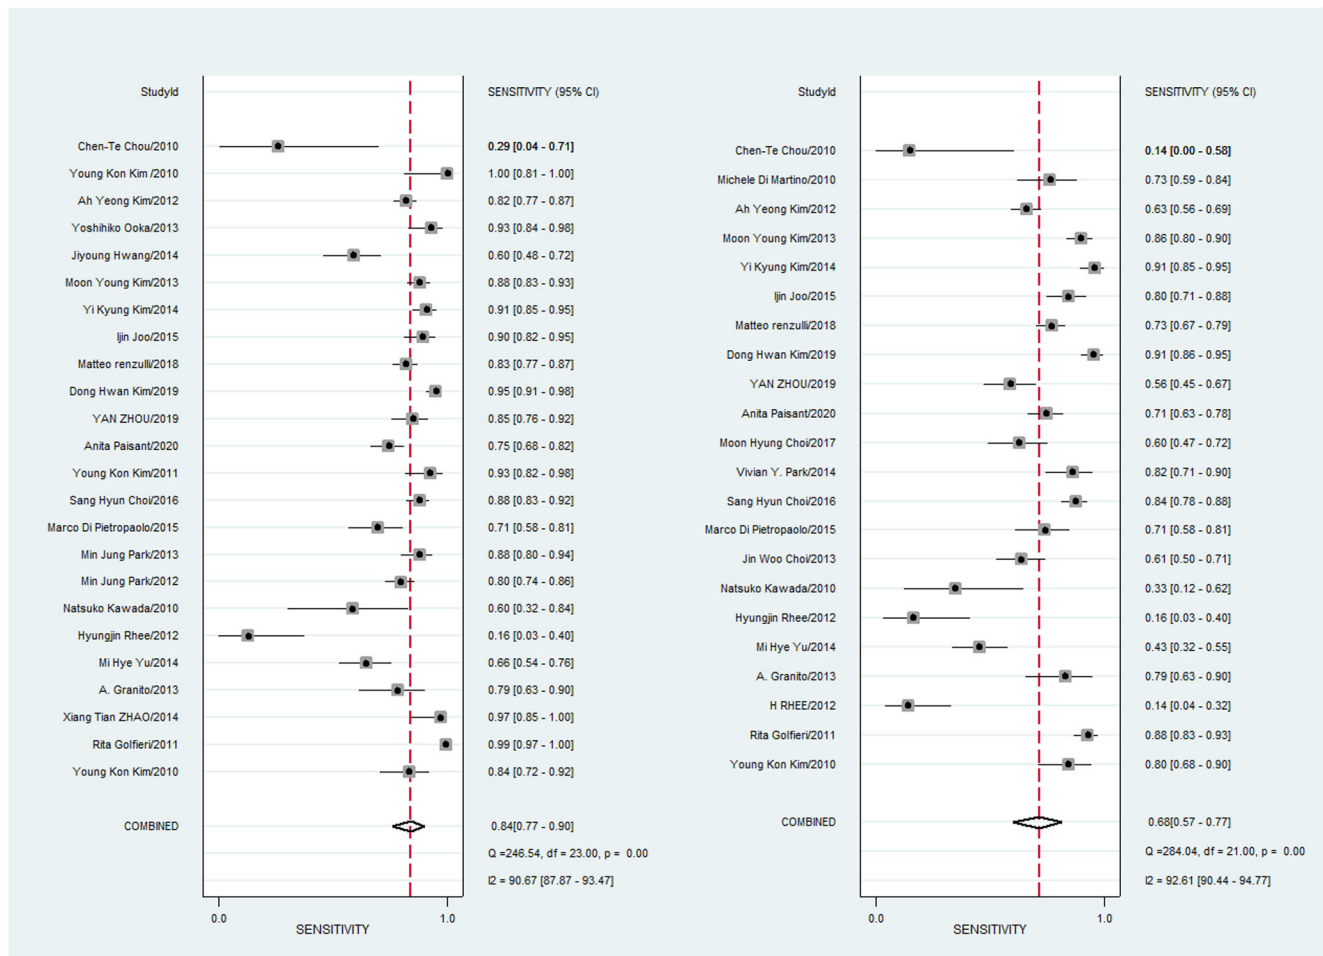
Summary sensitivities for Gd-EOB-DTPA-enhanced MRI with and without HBP
